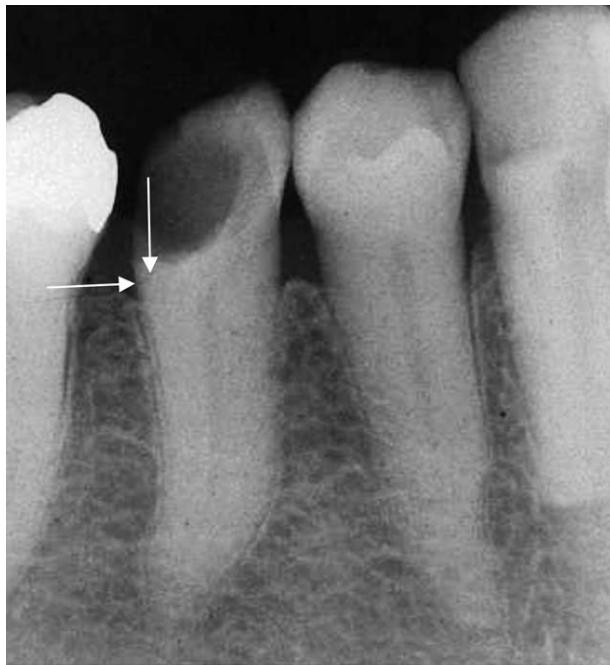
Preoperative x-ray of tooth #45. After excavation of caries, the proximal cavity margin is located close to the alveolar crest (arrow).
